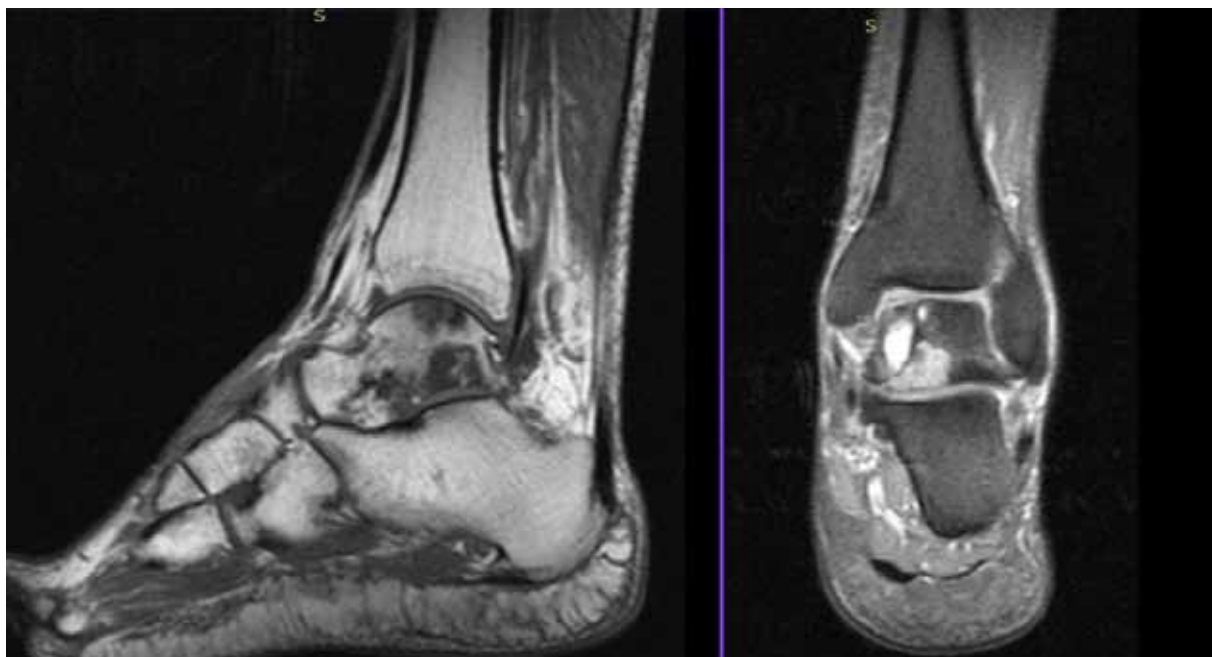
Preoperative MRI T1/PD TSE FS scans of the left talus bone in October 2017 revealing multiple cystic zones
